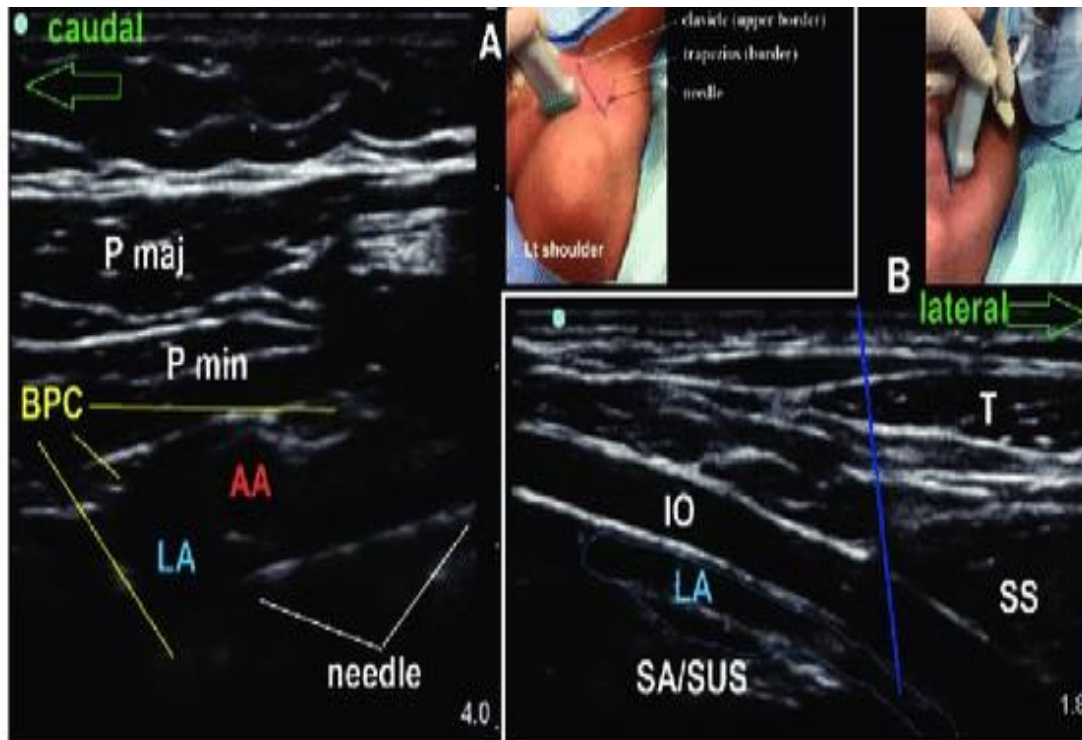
Ultrasound-guided infraclavicular subomohyoid nerve block: a medial-to-lateral probe movement is used to avoid the area where the needle advanced in the parasagittal plane could enter the pleura. On the left: Parasagittal lateral view: the serratus anterior is seen between the neurovascular bundle and the pleura. On right side appear subomohyoid muscle with needle tip beneath it(33).
